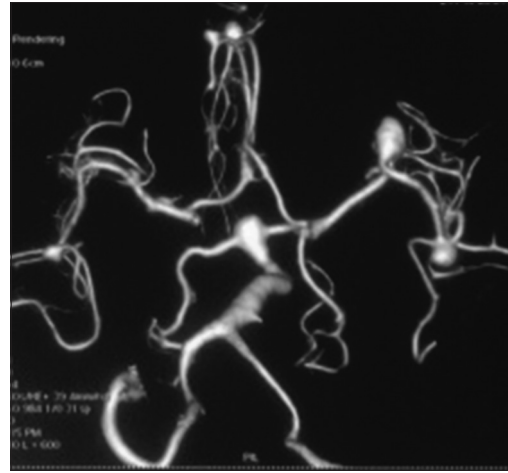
Computed tomography angiography volume rendering image showing multiple aneurysms
